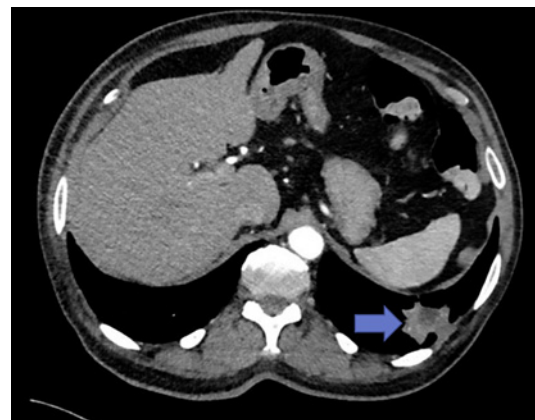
CT chest (mediastinal window) showed left lower lobe mass (blue arrow).
